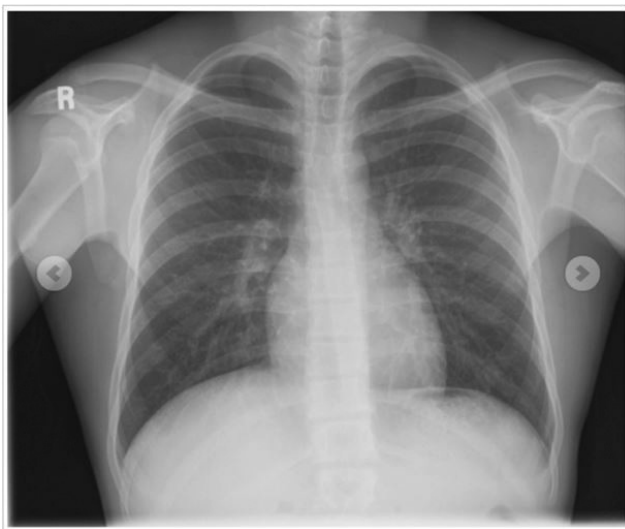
Original Lung X-Ray Image
